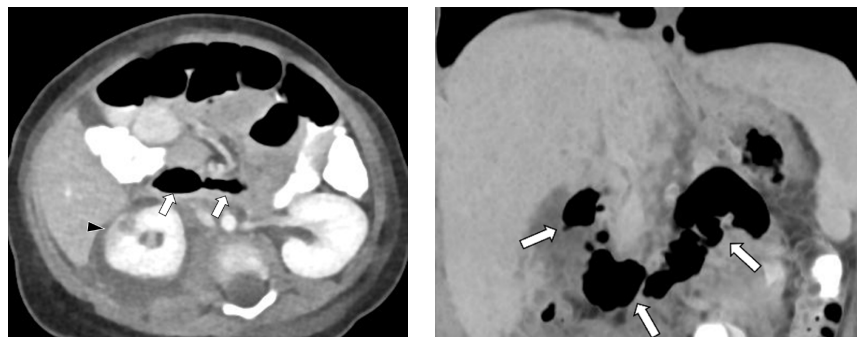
An infant presented to the emergency room with abdominal pain, fever, and a toxic appearance. CT with IV contrast was performed to evaluate the source of symptoms. Axial contrast-enhanced image with enteric contrast (left) and coronal minimum intensity projection (MinIP) image (right) show an air-distended duodenum (arrows). Note that the peripheral hypoenhancement in the right kidney is compatible with pyelonephritis (black arrowhead).
